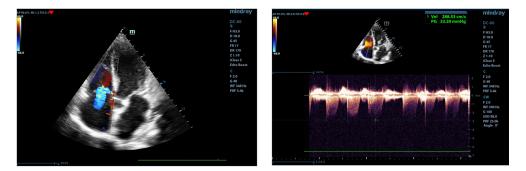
c.10. Moderate tricuspid regurgitation (left, color Doppler, 4chambers view) and maximum gradient between right atrium and right ventricle of 33 mmHg (right, CW Doppler, 4-chambers view)
